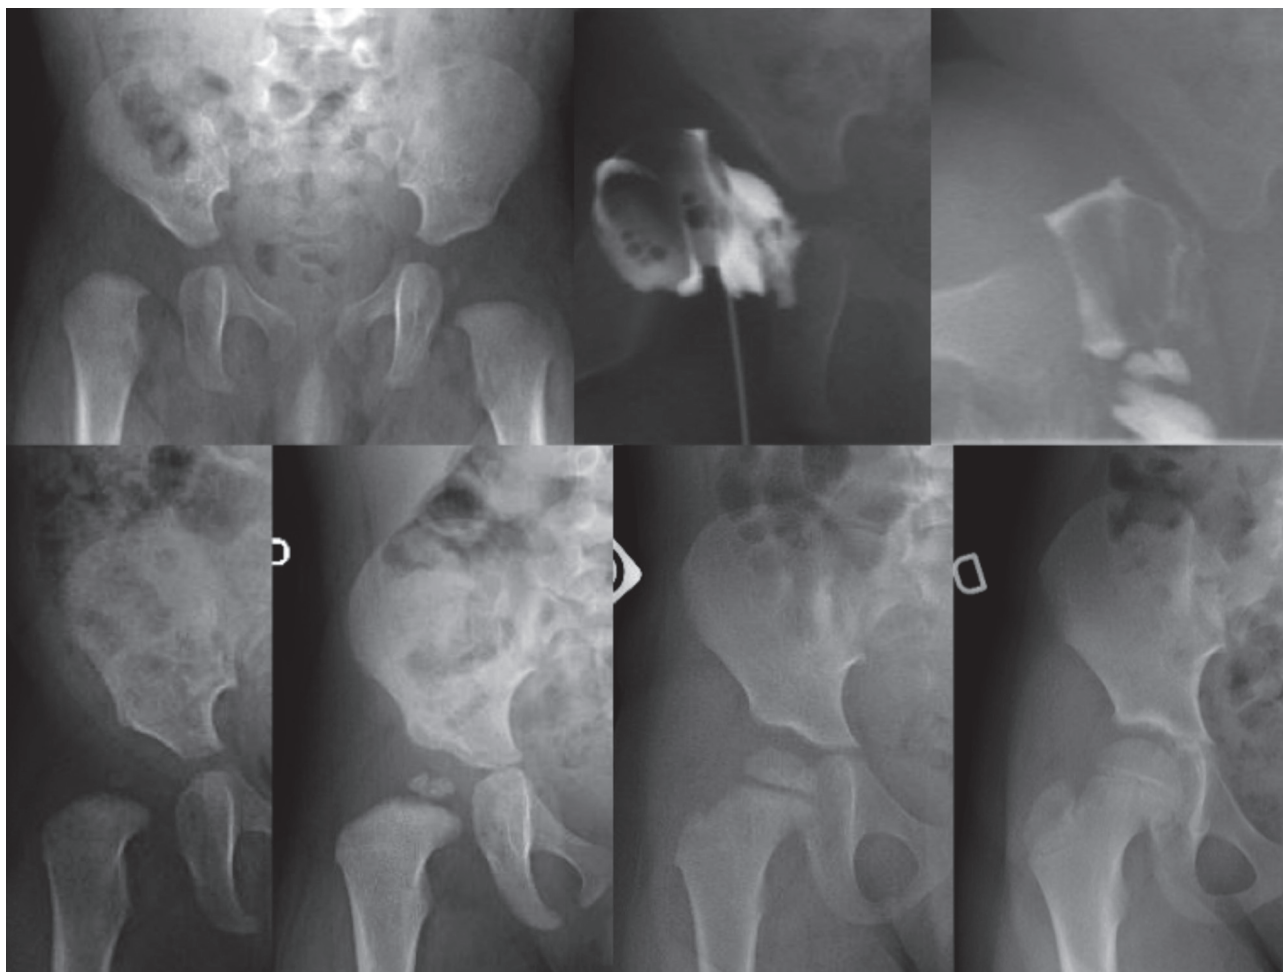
Example of a closed reduction without need of additional surgery. 2A-B. 4-month-old girl with right Tonnis-grade 2 hip dislocation. After 8-day-overhead traction, the hip was closely reduced. 1C. Reduction was scored grade 1. 1D: radiograph at the age of 11 months. 1E: radiograph at the age of 17 months. 1F: radiograph at the age of 3 years. 1G: radiograph at the age of 7 years and 6 months.
